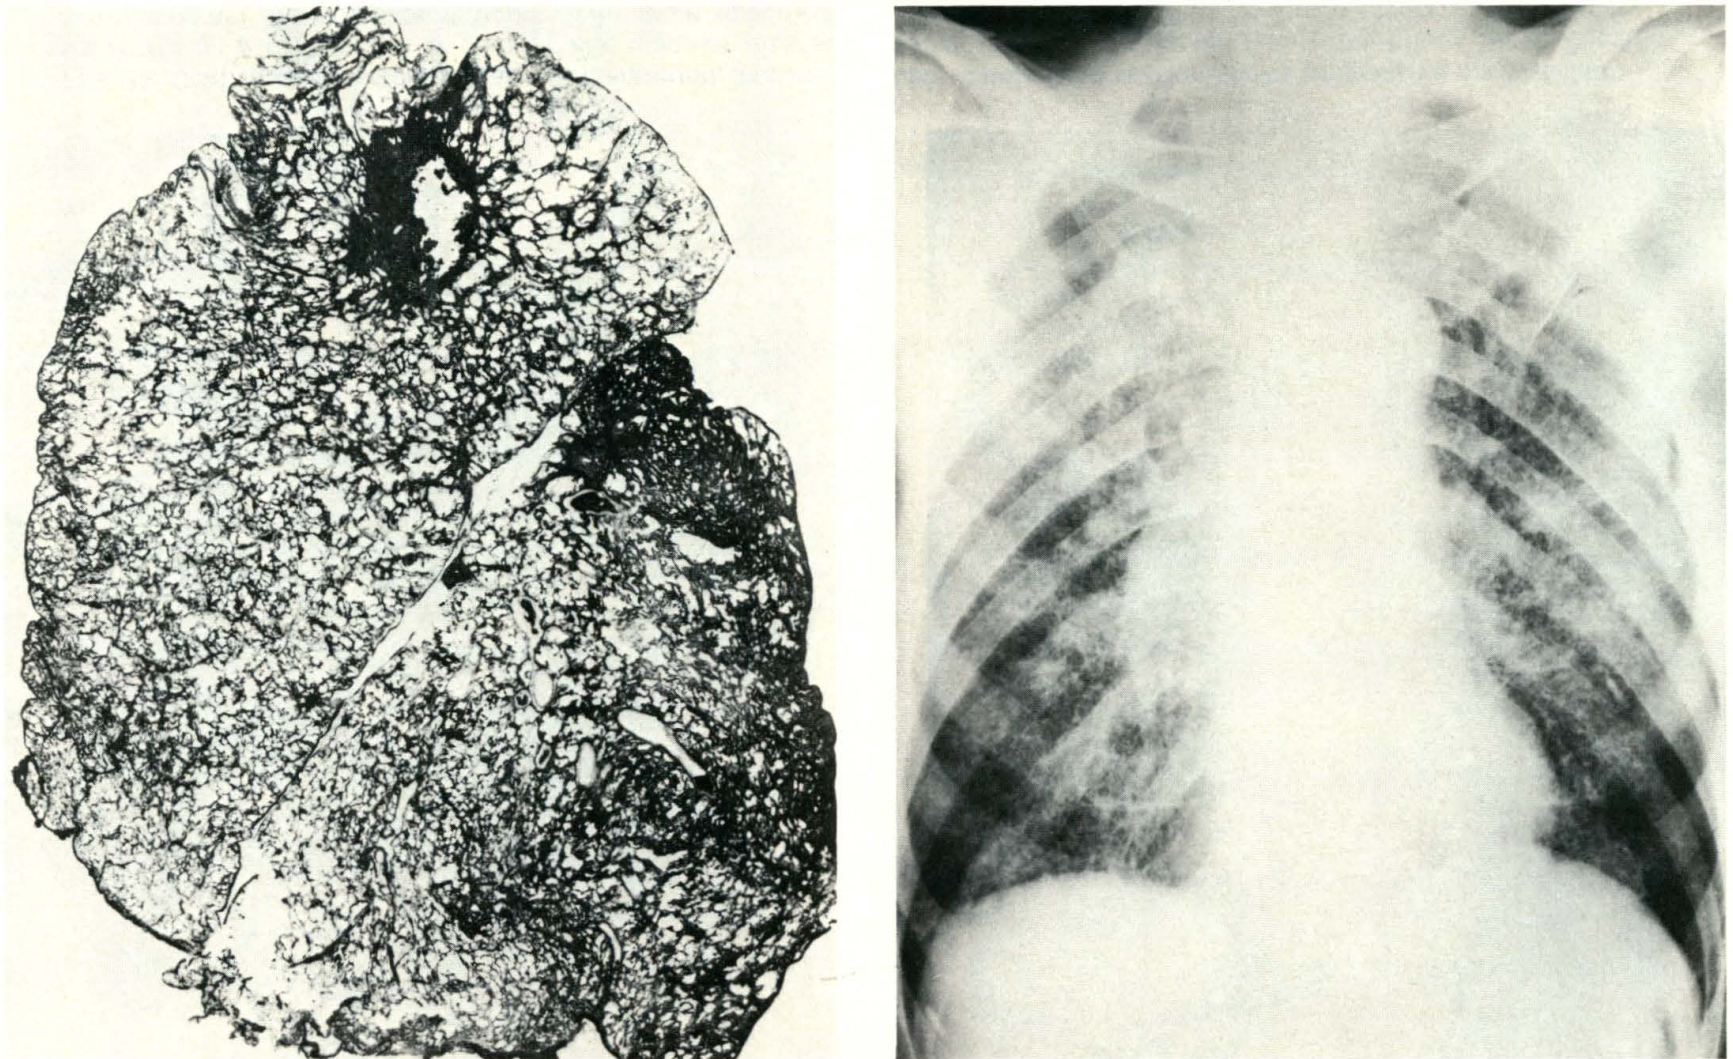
A 62-year-old Caucasian miner, worked 10 years underground as a loader and 24 years above ground as a checkweighman. Left. Whole lung section shows cavitating progressive massive fibrosis. The lesion transects the lobar fissure. Micronodules, macronodules, and macules are also present. Right. Chest roentgenogram shows bilateral ill-defined opacities consistent with complicated coal worker's pneumoconiosis category B on a background of category 2r round and 2u irregular small opacities. There is marked distortion of the pulmonary vessel markings.
